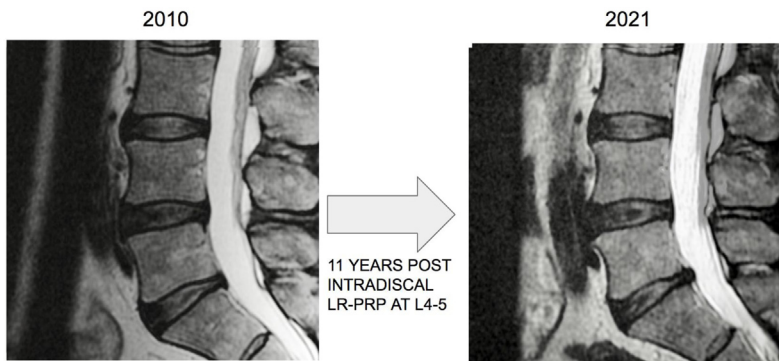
Images on top are CT-discogram axial and sagittal images of the first patient I ever treated with intradiscal LR-PRP revealing significant annular disruption of the L4-5 disc. Images below are T2 sagittal MRI images from the same patient treated from before and 11 years after treatment showing no signs of disc degeneration at the treated L4-5 level.
